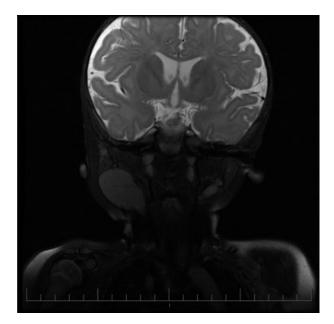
MRI-Coronal T2 weighted image.
